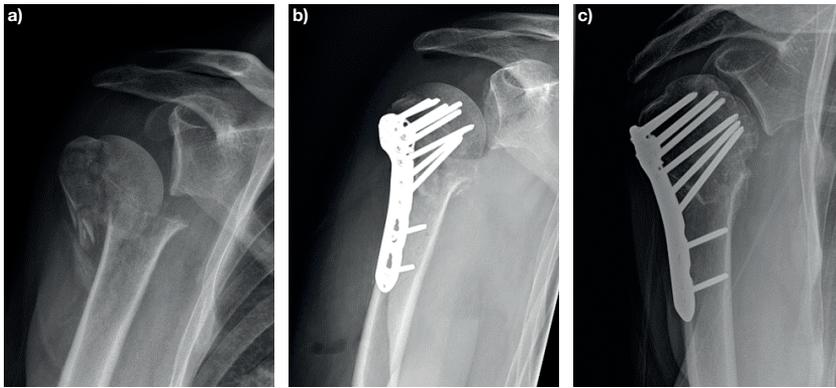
Radiographic example of avascular necrosis. a) Pre-operative radiograph. b) Post-operative radiograph following fixation with an anatomical plate. c) Six months post-operative. Interruption of the blood supply have led to subchondral collapse of the humeral head. Patient presented with pain, poor range of motion and mechanical symptoms, and is pending reoperation with extraction of the plate and replacement with a reverse shoulder arthroplasty.
